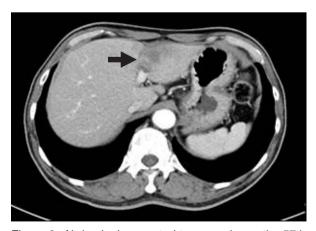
Abdominal computed tomography on the 57th day post pigtail catheter insertion revealed an ill-defined hypodense lesion (black thick arrow) at left lobe of the liver.
